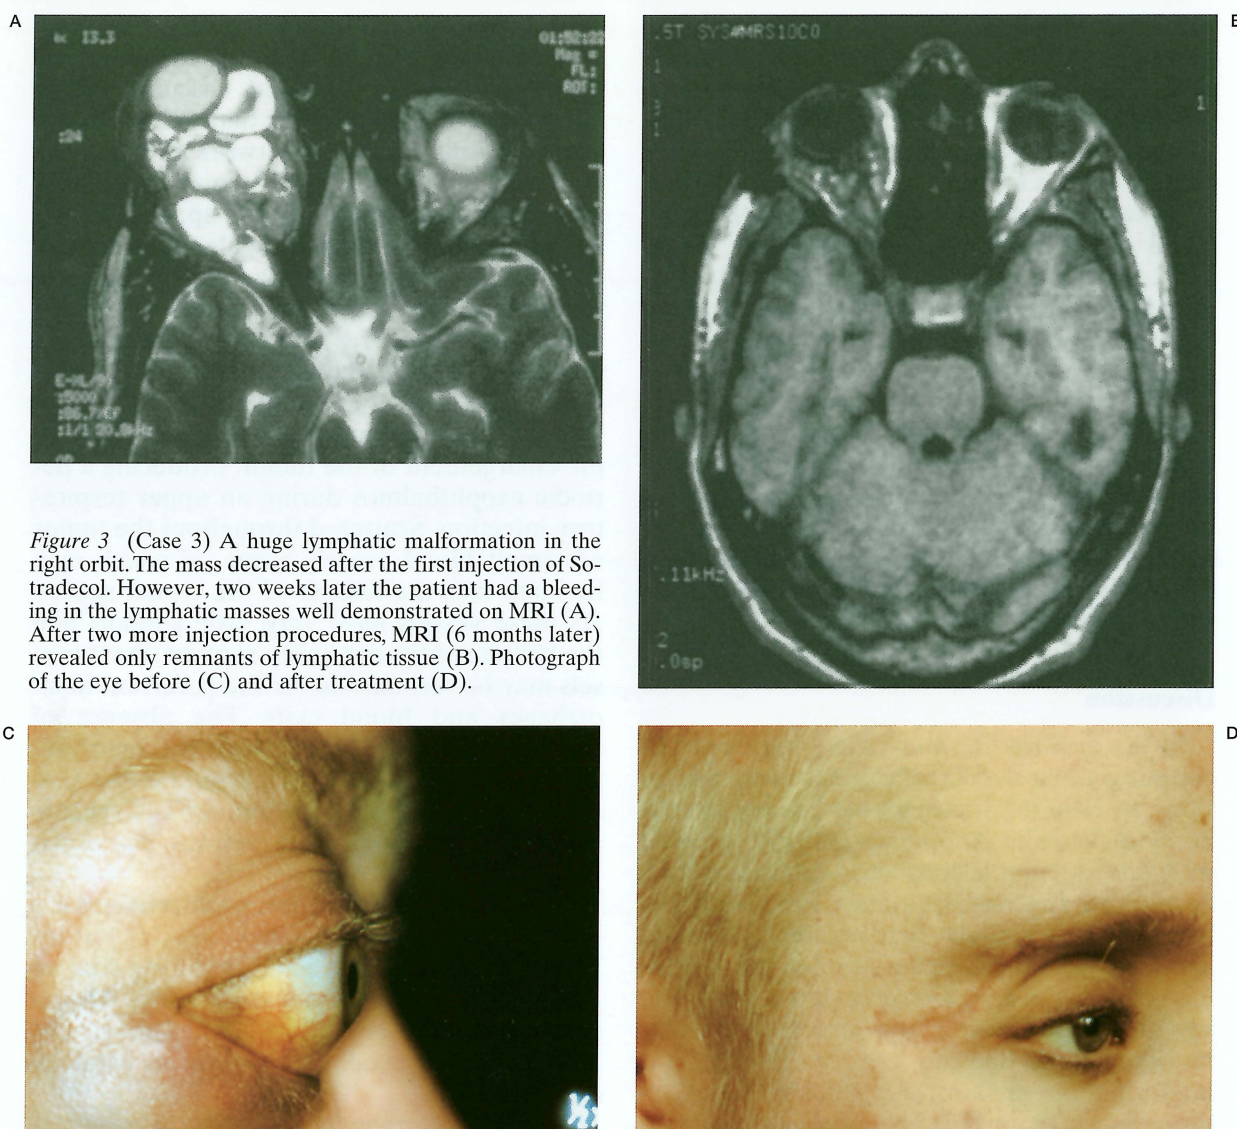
(Case 3) A huge lymphatic malformation in the right orbit. The mass decreased after the first injection of Sotradecol. However, two weeks later the patient had a bleeding in the lymphatic masses well demonstrated on MRI (A). After two more injection procedures, MRI (6 months later) revealed only remnants of lymphatic tissue (B). Photograph of the eye before (C) and after treatment (D).
